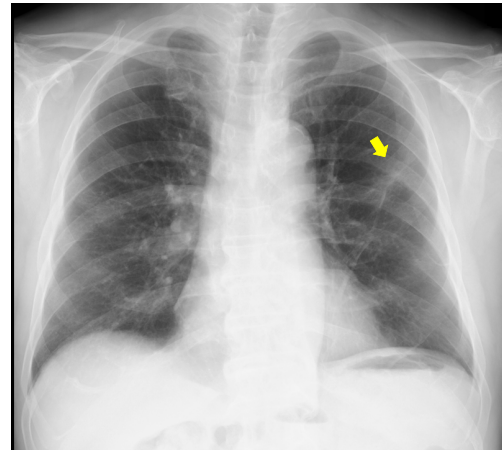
Digital Chest Radiograph Showing trabecular shadow in Left Superior Lobe in Patient with Lung Cancer
